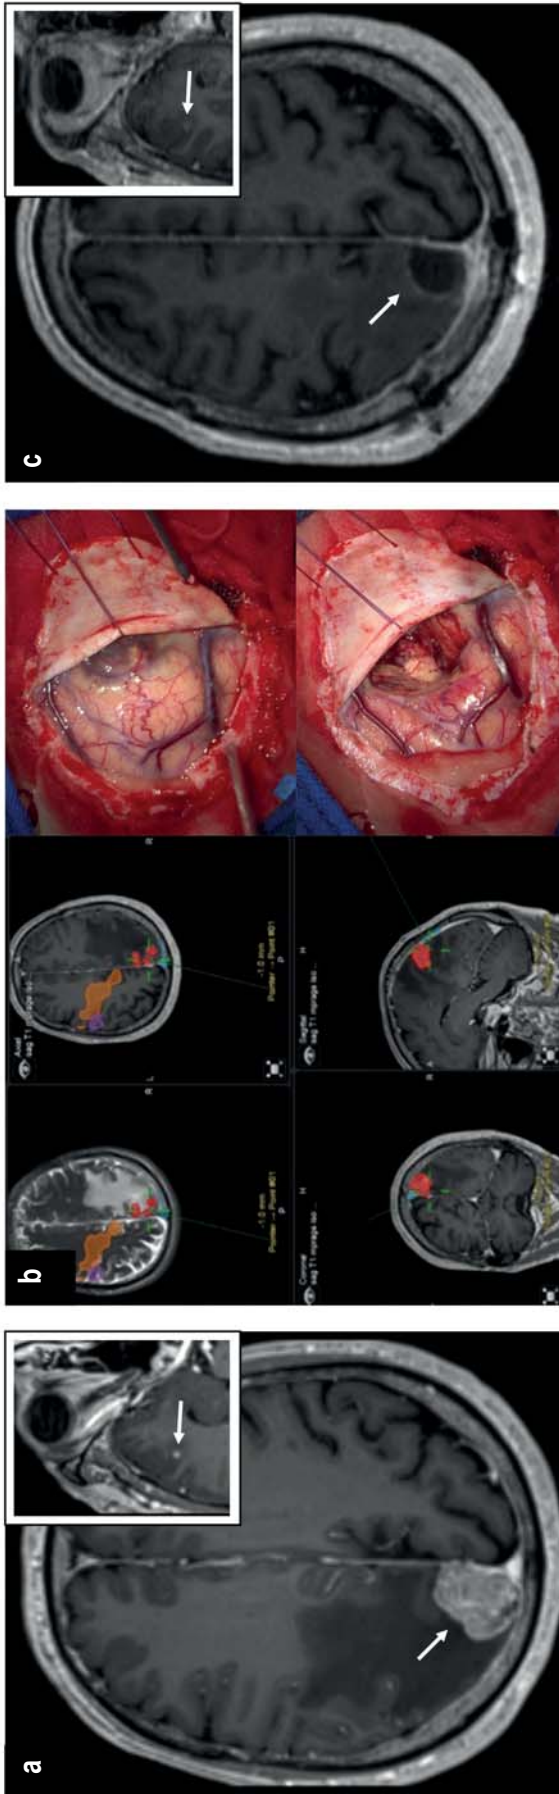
Combined surgery and radiotherapy in a 72-year-old man with melanoma who presented with two brain metastases: a) a right parietal metastasis with marked perifocal edema and left hemiparesis (motor strength 4 out of 5) and a right temporal metastasis measuring 4 mm in diameter (inset). b) Neuronavigation (left) and intraoperative photo documentation both before and after (top/bottom right) complete resection of the parietal metastasis (arrows). c) MRI follow-up six weeks after stereotactic irradiation of the resection cavity according to the VMAT scheme (total dose 25 Gy, in 5 fractions of 5 Gy each) and single-session radiotherapy of the temporal metastasis (1 x 20 Gy at the 80% isodose), followed by immunotherapy as directed by a dermatato-oncologist. VMAT, volumetric intensity-modulated arc therapy.
